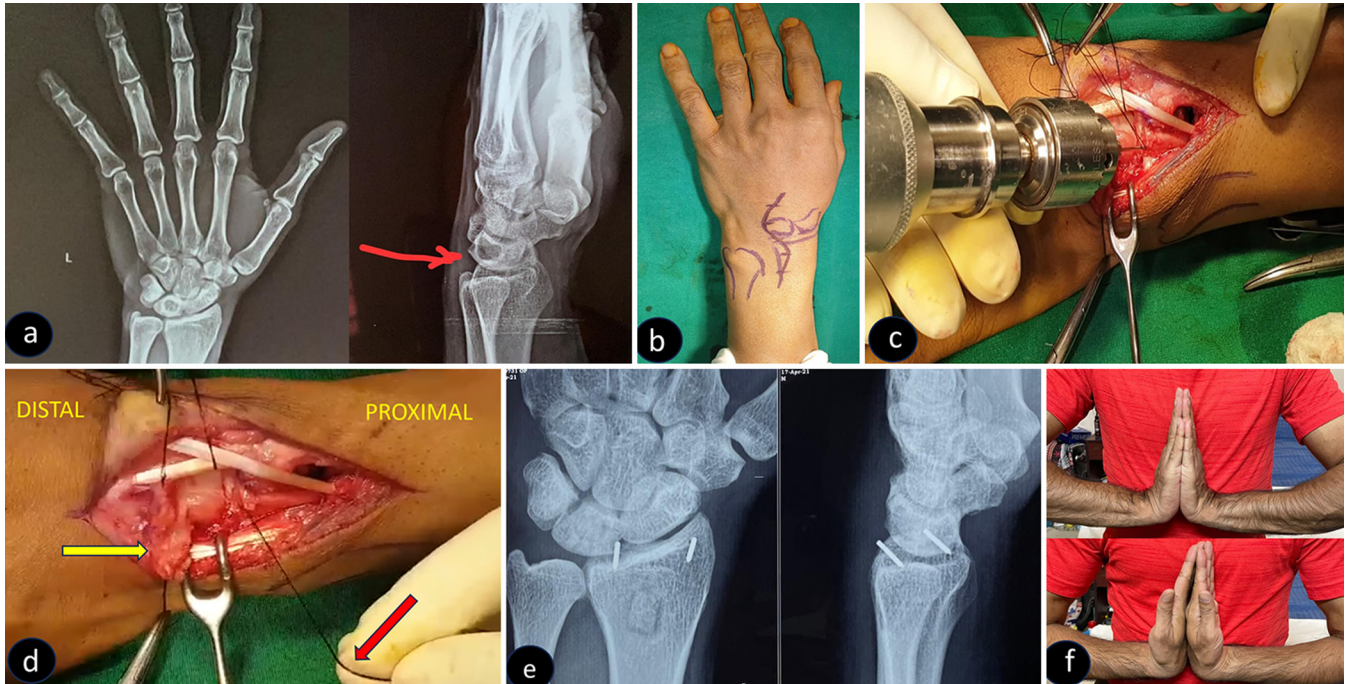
(a) Radiograph showing lytic lesion of lunate bone in anteroposterior and lateral views (red arrow). (b) Clinical picture showing the planned surgical incision. (c) Intraoperative picture showing the introduction of our suture anchor. (d) Intraoperative picture showing distal-based dorsal capsular reflection (Yellow pointer). Picture of an anchor being pulled by the surgeon (Red pointer). (e) Two-year follow-up radiograph showing healed lytic lesion of the lunate and healed bone graft donor site. (f) Two-year follow-up clinical picture showing a good range of movement at the wrist joint.
